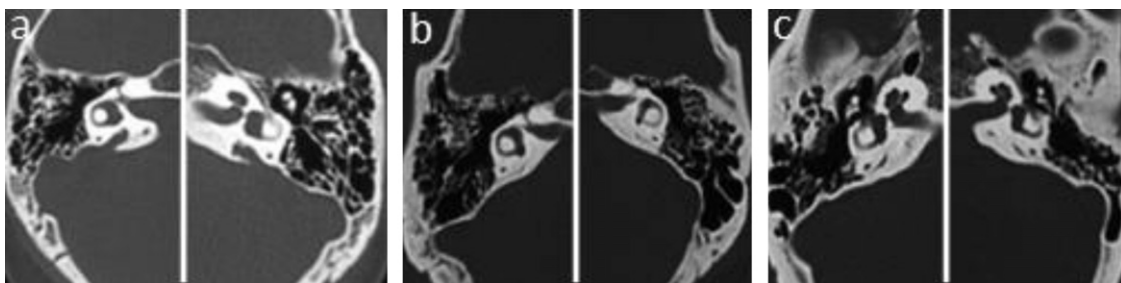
Temporal bone images of the family. (A): Temporal bone CT scan showed that the patient had a bilateral enlarged vestibular aqueduct (EVA). (B): Normal temporal bone CT scan of the father. (C): Normal temporal bone CT scan of the mother.
